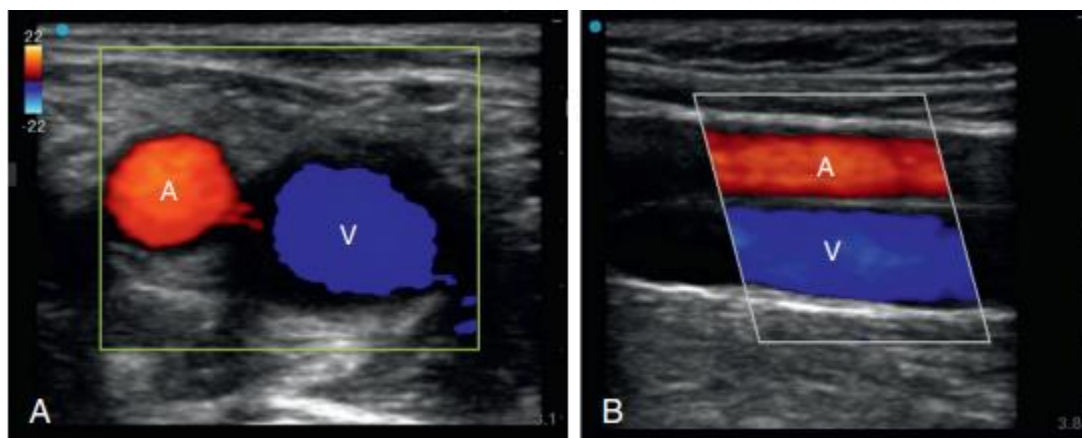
COLOR FLOW DOPPLER SHOWING FLOW AND VELOCITY.
